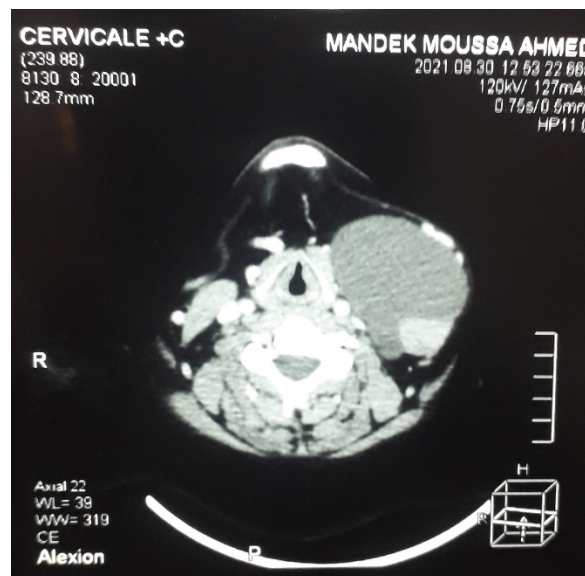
Axial CT of the neck: well-limited cystic formation on the left neck.
